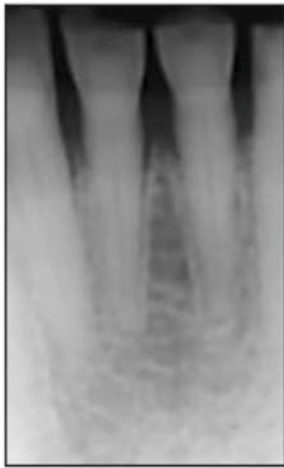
Periapical radiograph of anterior teeth with attrition.
